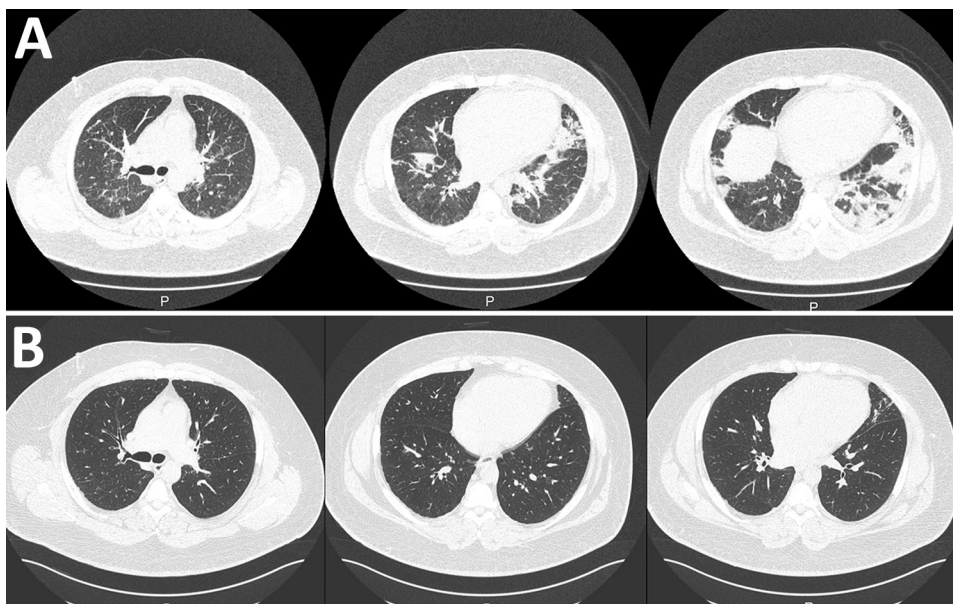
Chest computed tomography (CT) images of a male patient in Japan who was hospitalized with multisystem inflammatory syndrome. A) CT performed at hospital admission revealed infiltration in bilateral lower lobes. B) Chest CT performed a month after discharge revealed that most of these lesions had resolved.
